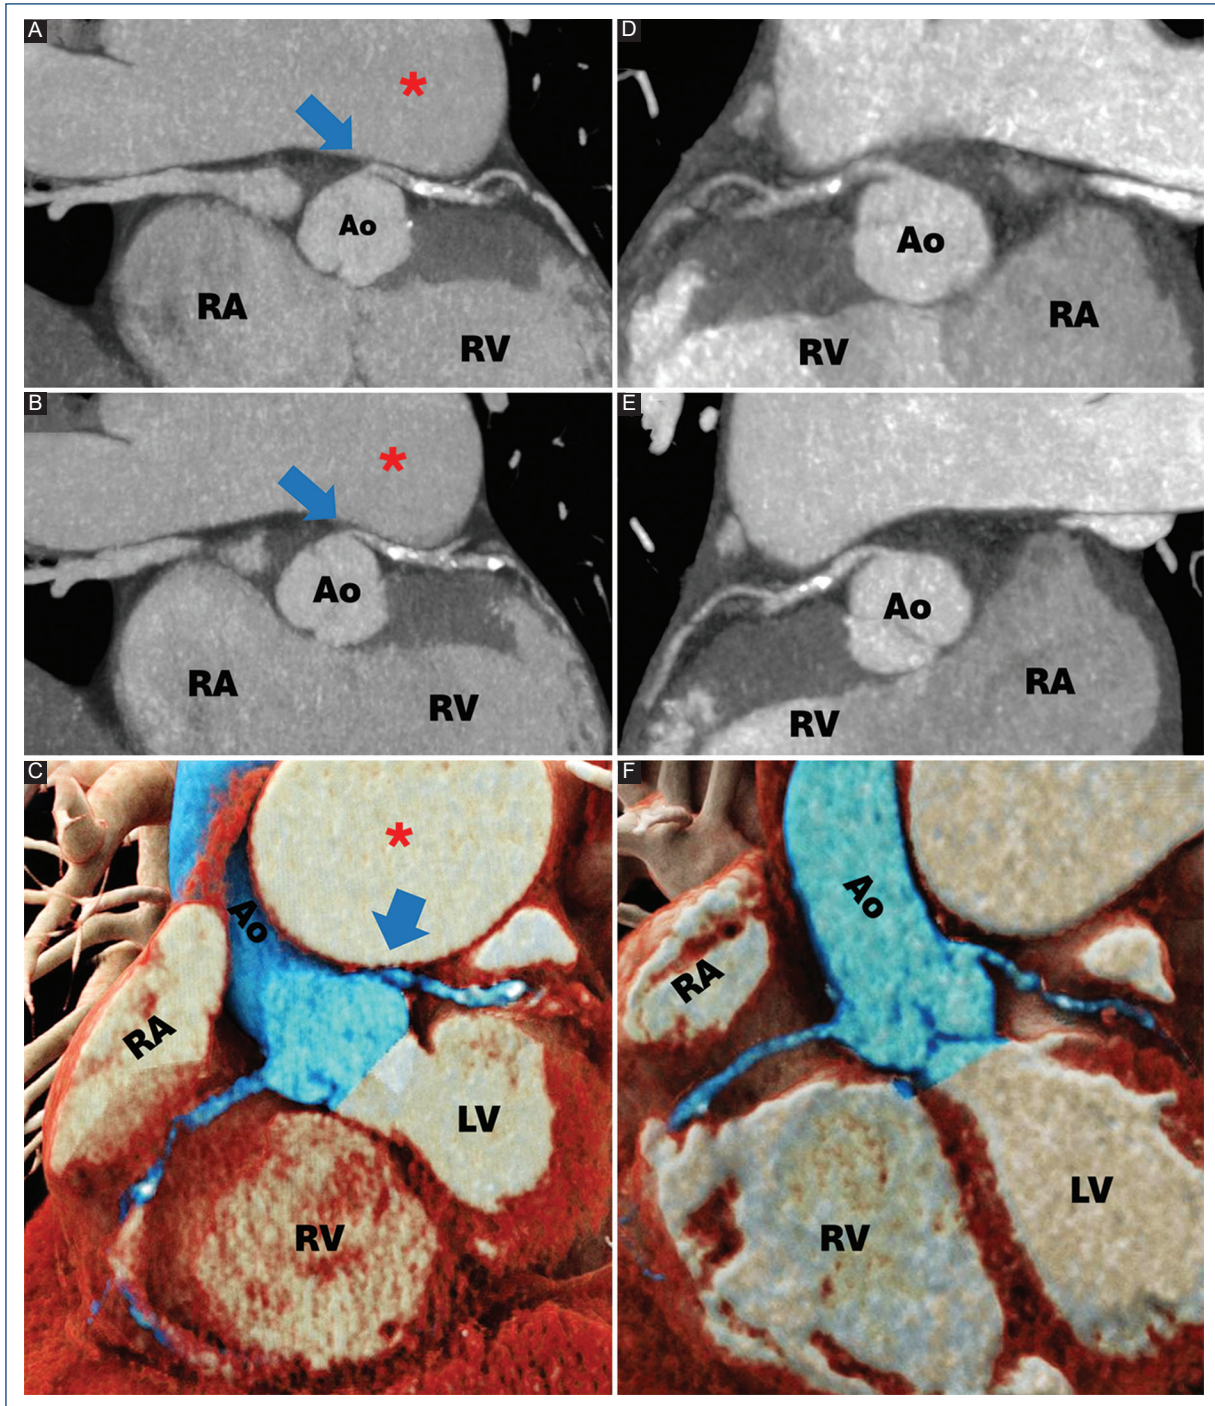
Cardiac CT demonstrating PAA (red asterisk) compressing the left main coronary artery (blue arrow). A: MIP imaging in systole. B: MIP imaging in diastole. C: 3D volume-rendered imaging. Cardiac CT after pulmonary artery plication: D: MIP imaging in systole. E: MIP imaging in diastole. F: 3D volume-rendered imaging. Ao: aorta; CT: computed tomography; LV: left ventricle; MIP: maximum intensity projection; PAA: pulmonary artery aneurysm; RA: right atrium; RV: right ventricle.
